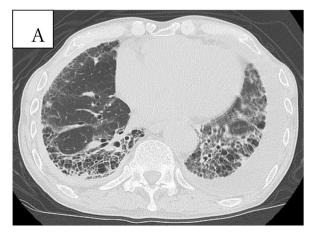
Chest computed tomography showing bronchiectasis and ground-glass opacities in bilateral lung bases, along with pleural effusion.
